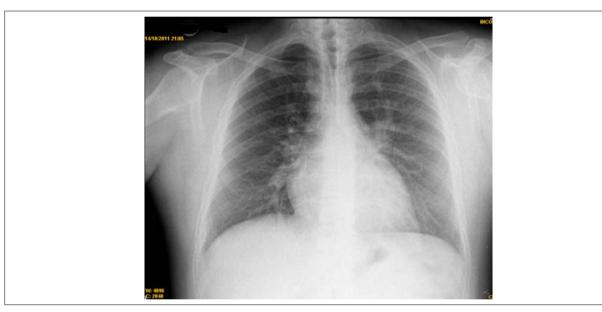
PA Chest X-ray: normal
